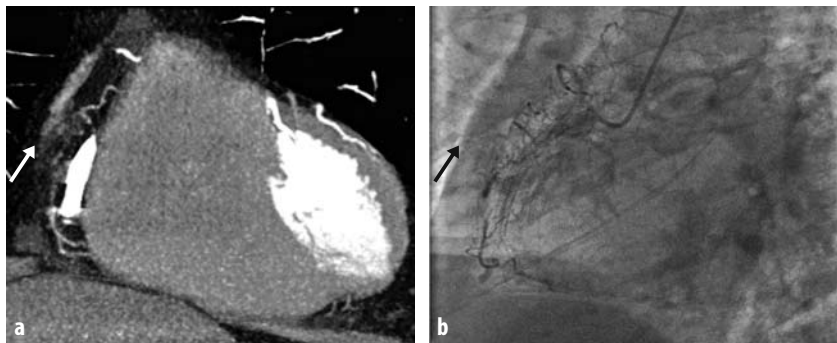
a-c. Collateral circulation from the LAD shows revascularization distal to the occlusion of the right coronary artery. a, b Three-dimensional images acquired with CT. c Catheter coronary CT angiography shows small collateral vessels and revascularization of the distal right coronary vessel
